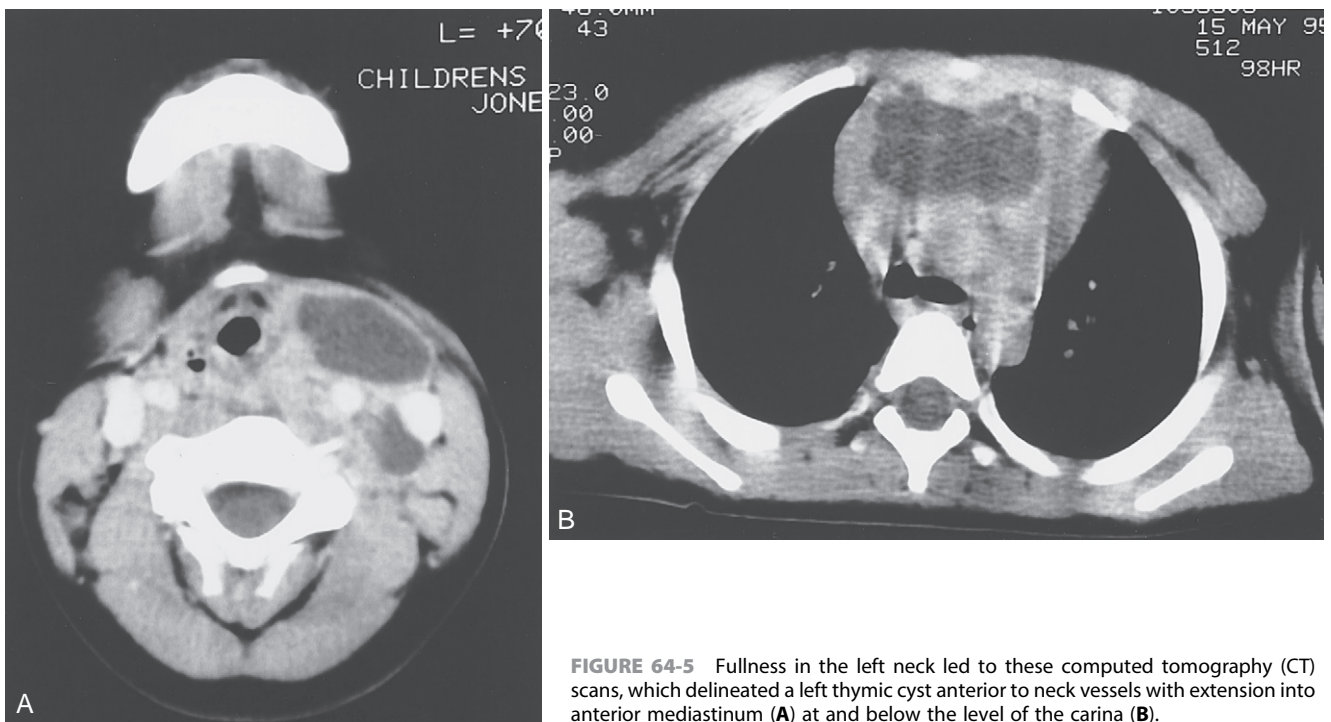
Fullness in the left neck led to these computed tomography (CT) scans, which delineated a left thymic cyst anterior to neck vessels with extension into anterior mediastinum (A) at and below the level of the carina (B).
